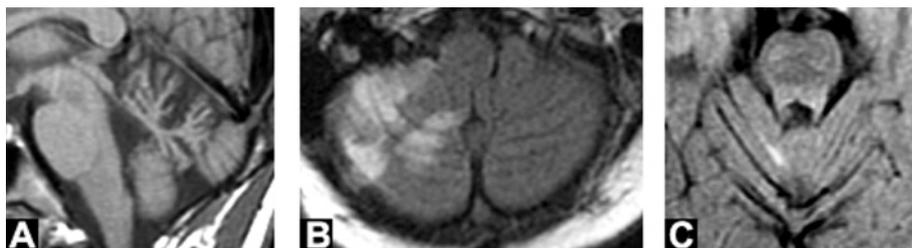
MRI of the cerebellum. (A) T1-weighted sagittal image of case 9 with hypoplasia of the cerebellar vermis. (B) Diffusion weighted image in case 10 with infarction identified in the lateral and medial aspects of the cerebellar posterior lobe including lobule IX. (C) Axial FLAIR image in case 11 showing encephalomalacia of the superior vermis on the right, and mild hemiatrophy of the right pons.
